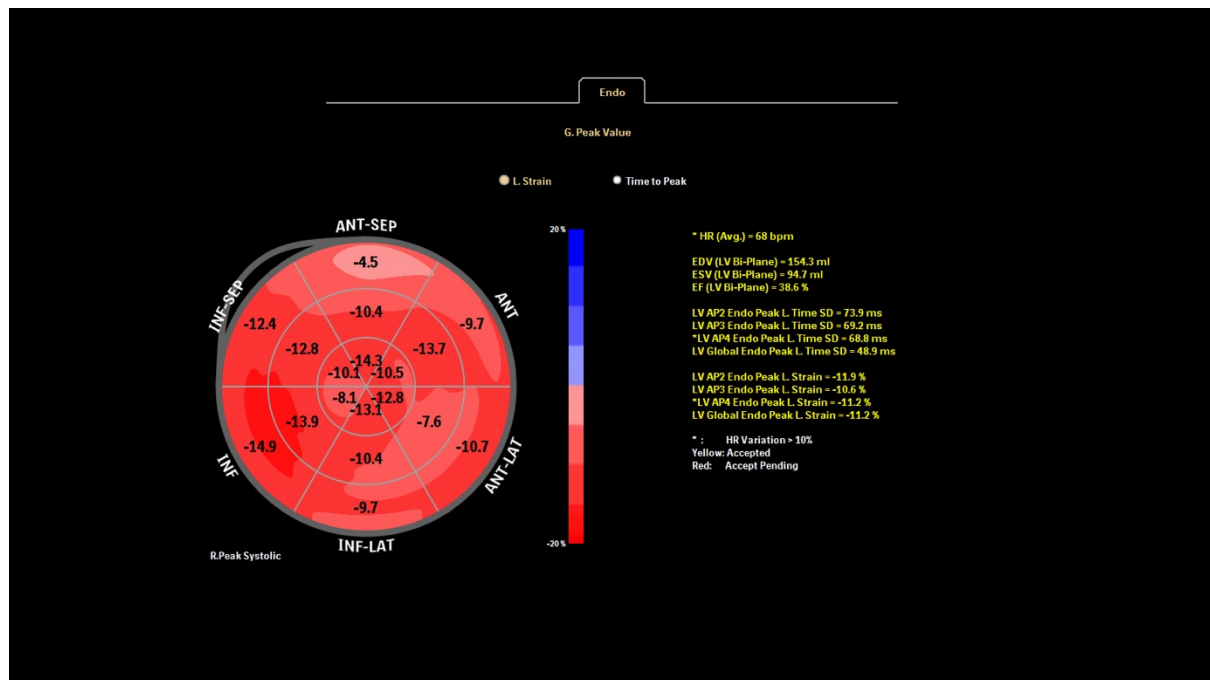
Two-dimensional speckle tracking echocardiography showing reduced global longitudinal strain.
